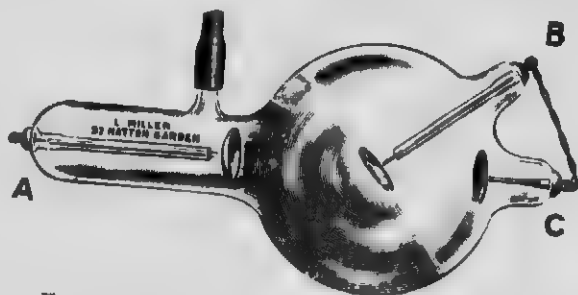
COMMON FORM OF X-RAY TUBE.
